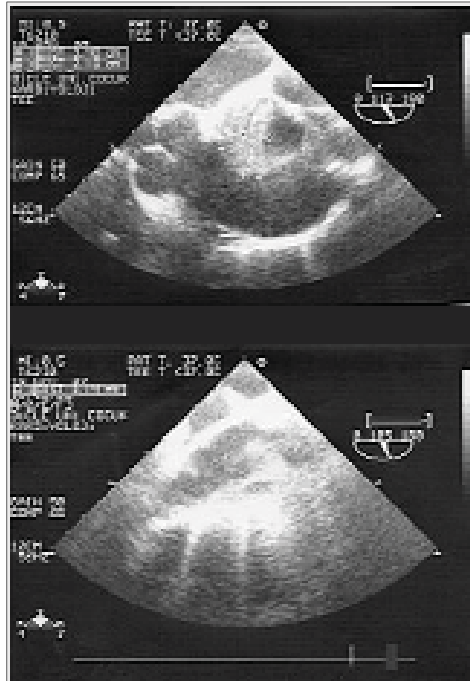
Calcified aortic aneurysm and the thick clot in transthoracic echocardiogram.
